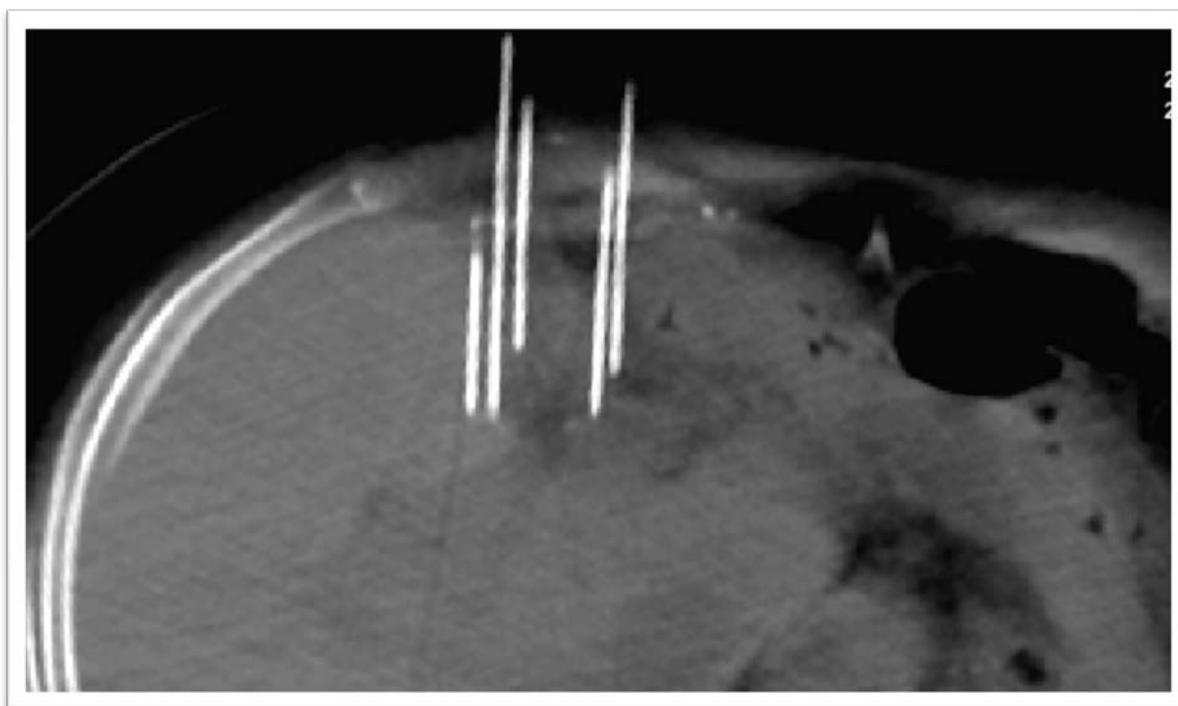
Electrochemotherapy procedure in a patient with intrahepatic cholangiocarcinoma (controlled by computed tomography).
